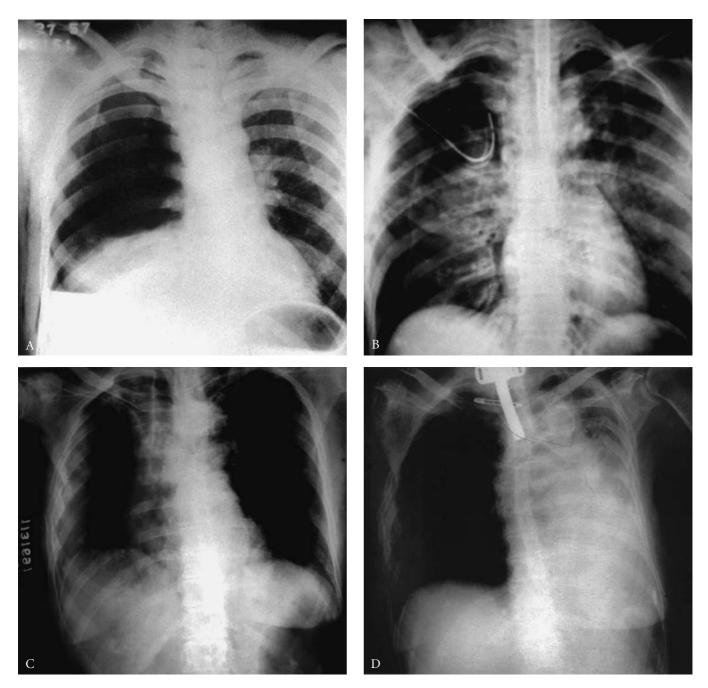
Variations in radiographic picture obtained following main bronchial rupture. A, Complete right main bronchial rupture with lung collapsed at the base of hemithorax, since it remains connected to the hilum only by pulmonary vessels. Tension is indicated by mediastinal displacement. Hemothorax is present. B, Partial expansion of lung on pleural suction after right main bronchial fracture, because peribronchial tissues maintain a partially "intact" air channel to the lung. This presentation is most commonly seen. Note the mediastinal emphysema and air in the muscle planes. C, Chest roentgenogram of a 69-year-old woman, run over by a truck. Multiple bilateral rib fractures and unstable chest wall. Mediastinal shift to right. Pleural obliteration prevented pneumothorax. D, Same patient after partial atelectatic collapse of left lung. Air delineates the transected left main bronchus.
